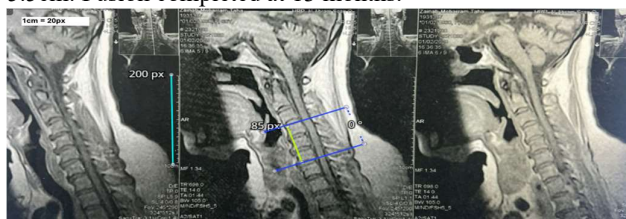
Case 5 Preoperative MRI T2 MRI sagittal view of cervical vertebrae
